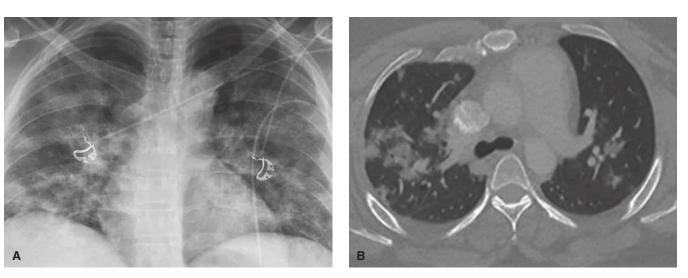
A. Chest radiograph of a critically ill pregnant woman at 26 weeks' gestation demonstrating diffuse bilateral pulmonary opacities with peripheral predominance. B. Axial image of the chest from a computed tomographic scan demonstrates advanced COVID-19 disease with multiple peripheral lobular consolidations and ground glass opacities.
